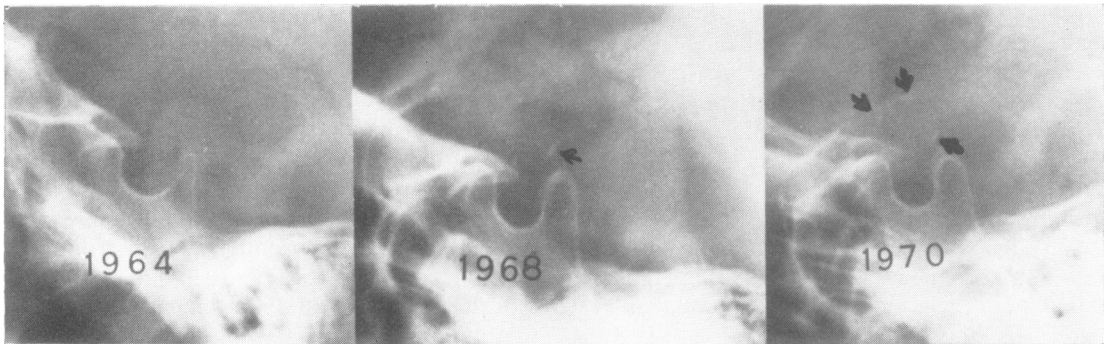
Case 2. Skull radiographs from 1964 to 1970 showing the gradual appearance of suprasellar calcification, this first appearing in 1968 and being much more marked by the time of the examination in 1970 (arrows).
